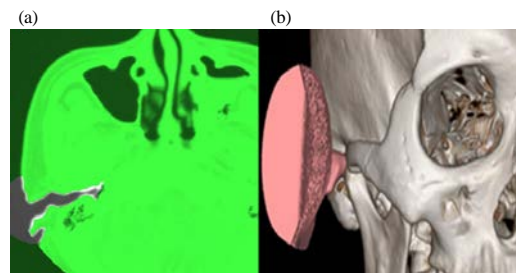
External auditory meatus extraction process using the temporal CT volume data
